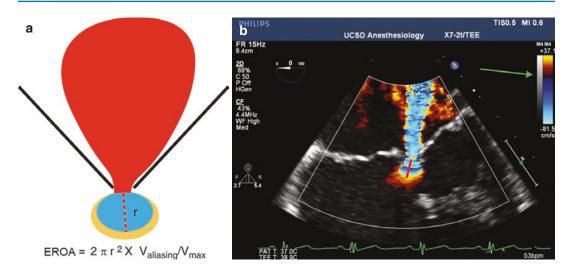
(a) Calculation of the EROA of MR by PISA. (b) PISA radius identification (*red line*) in a ME four-chamber view. Note the shifted color flow Doppler baseline and the identified aliasing velocity (*green arrow*)
